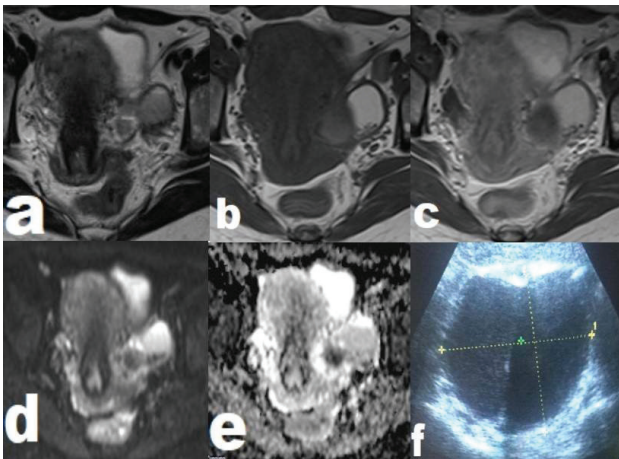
MRI and TVU images of endometriotic cysts of the left ovary
